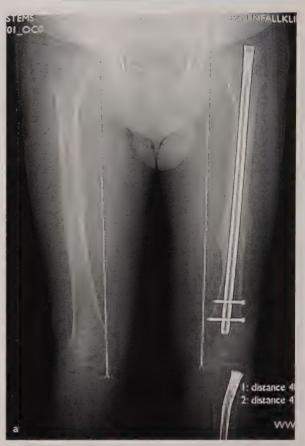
a, b A 62-year-old patient with external malrotation of 38° after intramedullary nailing of a femur shaft fracture 2 years before. c The osteotomy was performed using an intramedullary saw at the biomechanically most appropriate point. After nail insertion and derotation with the nail in situ, compression locking was applied. d The postoperative X-ray confirmed the good compression of the osteotomy. e, f Undisturbed bone healing confirmed by the X-ray controls after removal of the nail
